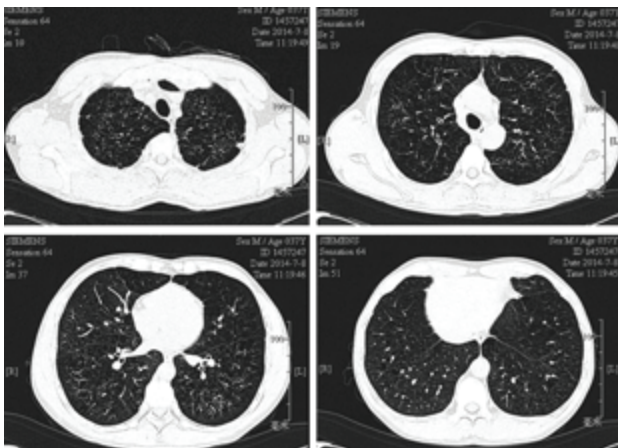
Thoracic HRCT showed a bilateral diffuse cyst, especially in upper lobe and middle lobe.
